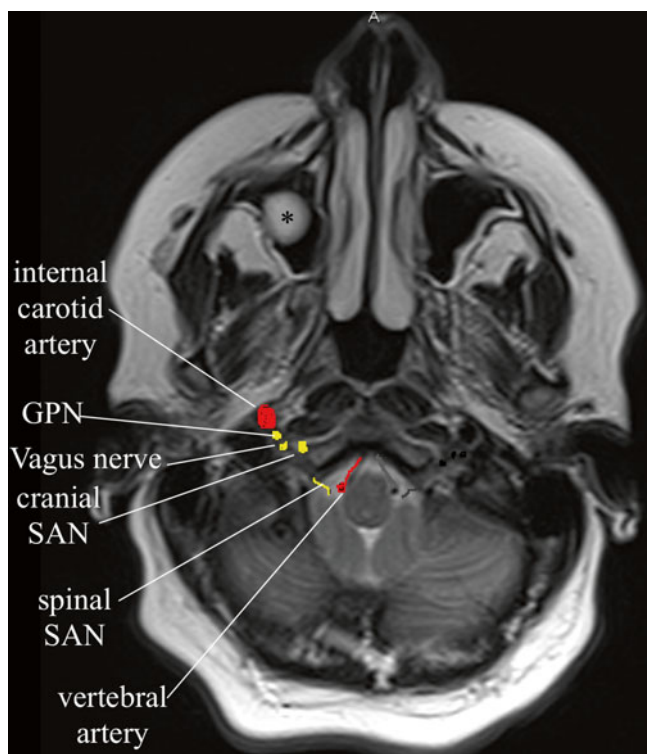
MRI axial image at the level of the foramen magnum. GPN glossopharyngeal nerve, SAN spinal accessory nerve (cranial and spinal divisions), * = incidental maxillary sinus cyst (Image courtesy of Andrea Trescot, MD)
